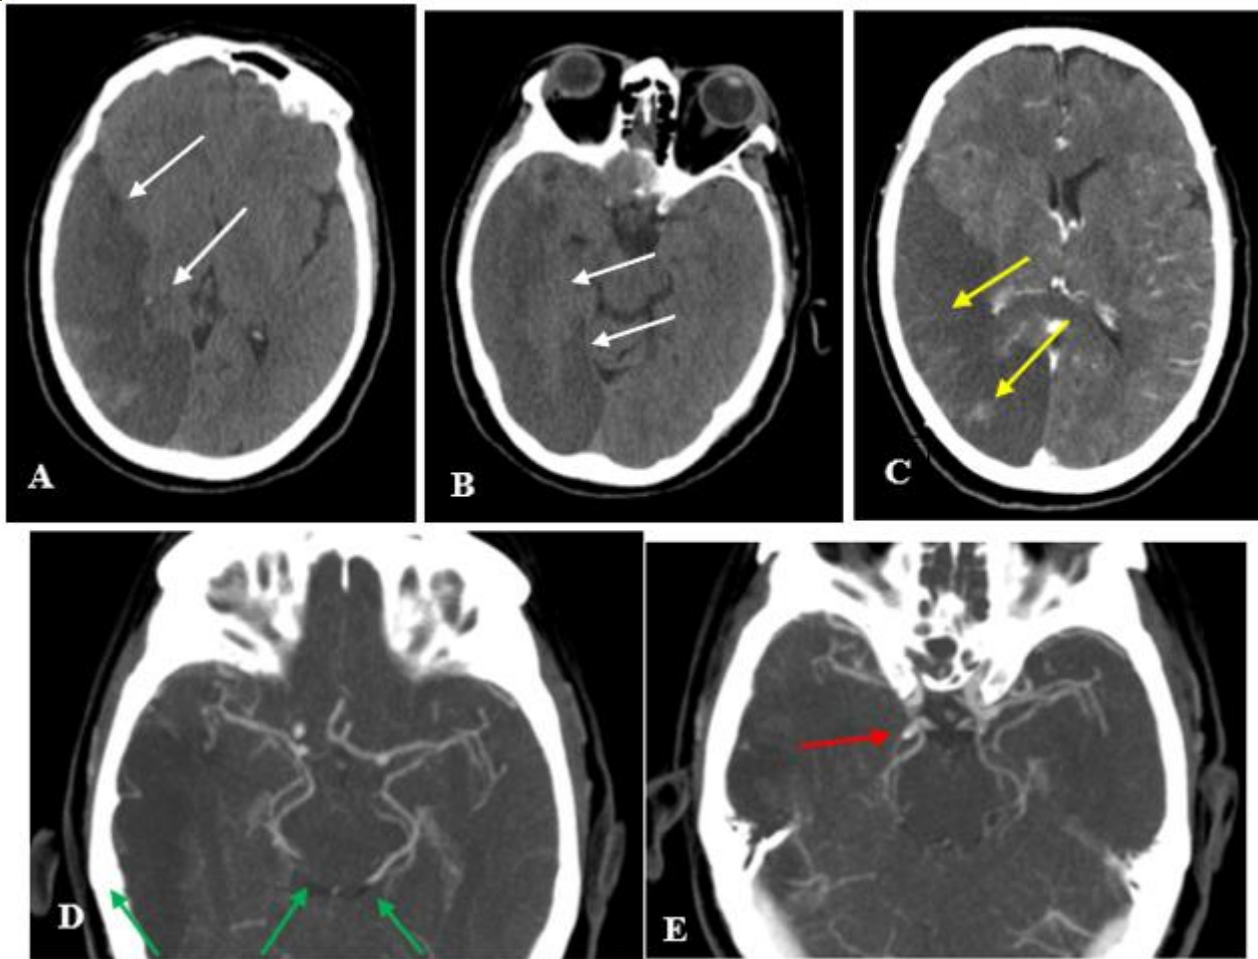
Axial images of brain CT scan without contrast (A,B) and with contrast (C,D) showing cortico-subcortical hypodensity areas (white arrows) in the right temporo-parieto-occipital region with gyriform enhancement (yellow arrows), accompanied by a slender appearance of the basilar trunk and absent P1 segment of both PCA (green arrows). It is associated with a slender morphology of the internal carotid artery in both its intracavernous and clinoid segments (red arrows)
